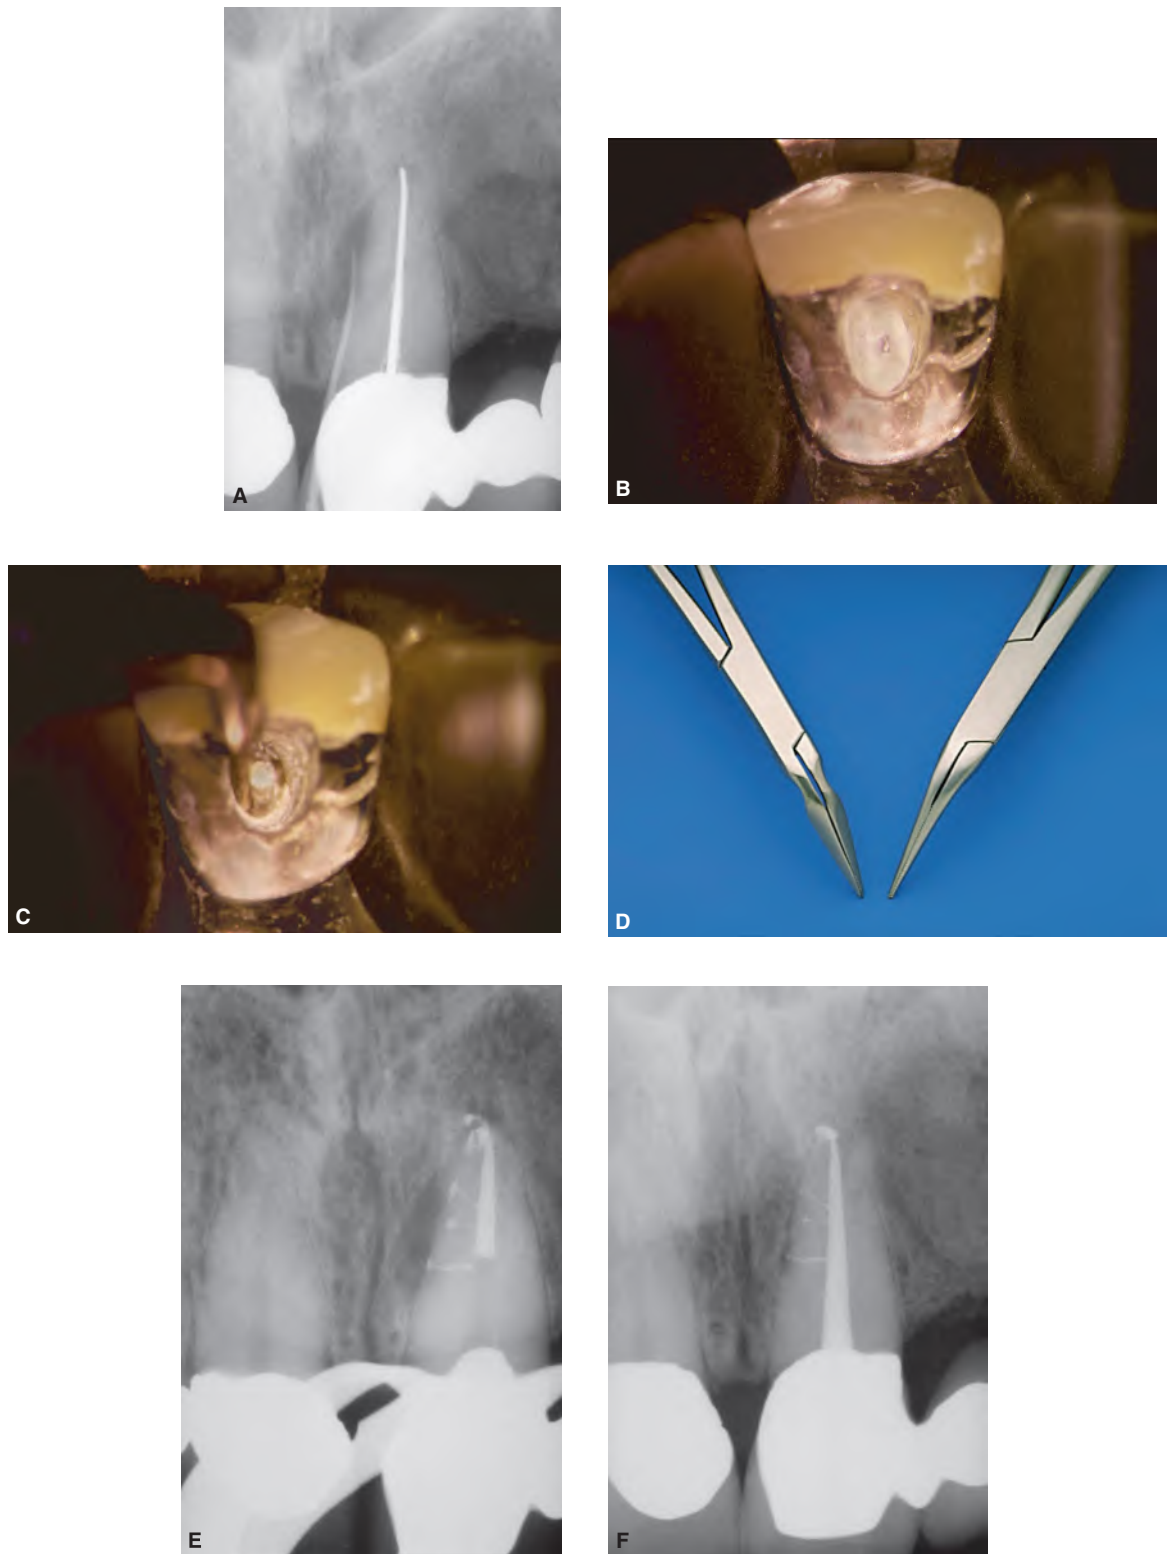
A. Preoperative radiograph depicting a failing endodontic treatment in the maxillary central incisor serving as a bridge abutment. A gutta-percha point tracing a fistulous tract to a large lateral lesion, and a canal underfilled and slightly overextended. B. Magnification at 15 \times reveals lingual access and restorative build-up around the coronal-most aspect of the exposed silver point. C. Magnification at 15 \times demonstrates the ProUltra ENDO-3 ultrasonic instrument removing material laterally to the silver point. D. The left image shows the Stieglitz pliers utilized for grasping intracanal obstructions. The right image shows the “modified” Stieglitz pliers whose working end has been machined down to enhance access. E. A working radiograph, taken during the downpack, reveals apical and lateral corkage. Note the thermosoftened and compacted gutta-percha is apical to the most coronally positioned lateral canal. F. Five-year follow-up radiograph showing the three-dimensional endodontic treatment promoted healing.
